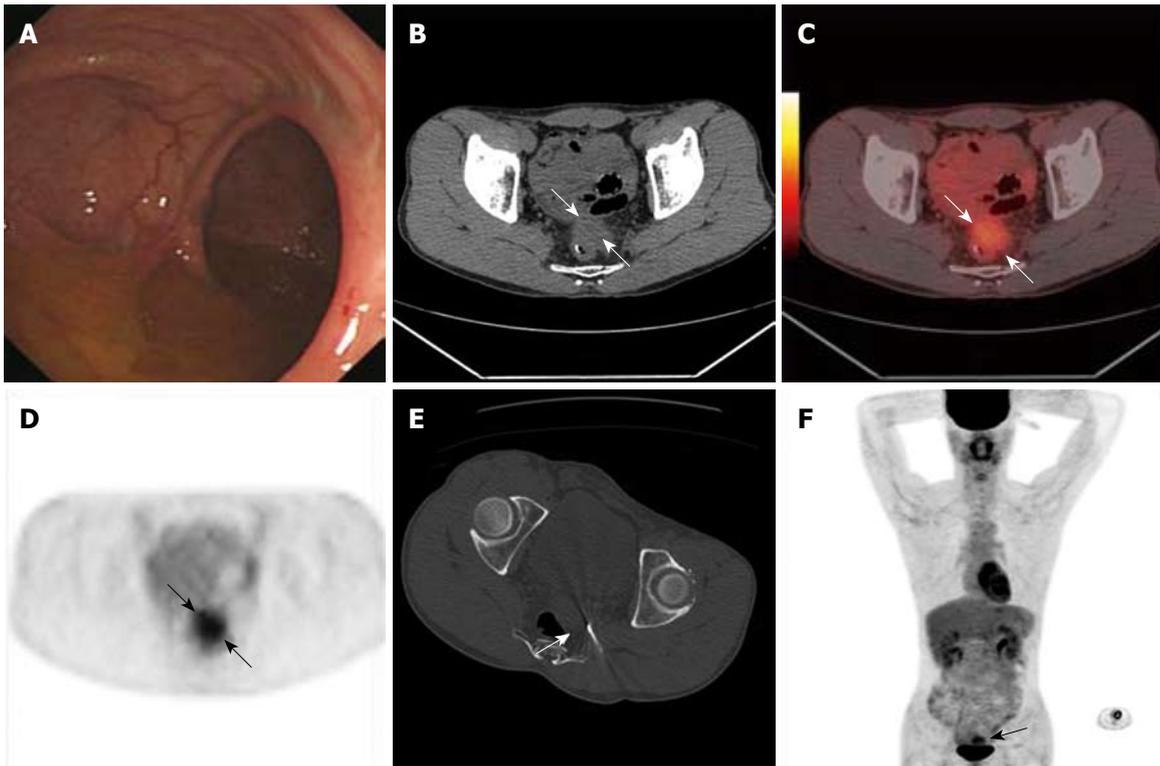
Perirectal recurrence. Endoscopic examination, transverse images and PET/CT images obtained 25 mo after surgery in a 39-year-old man. A: Colonoscopy at the level of tumor resection showed no evidence of recurrence; B: CT demonstrated perirectal soft tissue that might represent a local recurrent tumor or postoperative scar tissue (arrows); C, D: PET/CT revealed a perirectal lesion with high FDG uptake (arrows); E: Local recurrence was confirmed by PET/CT guided tissue core biopsy (arrow); F: Whole body PET/CT confirmed local recurrent tumor (arrow) and no distant metastasis.
